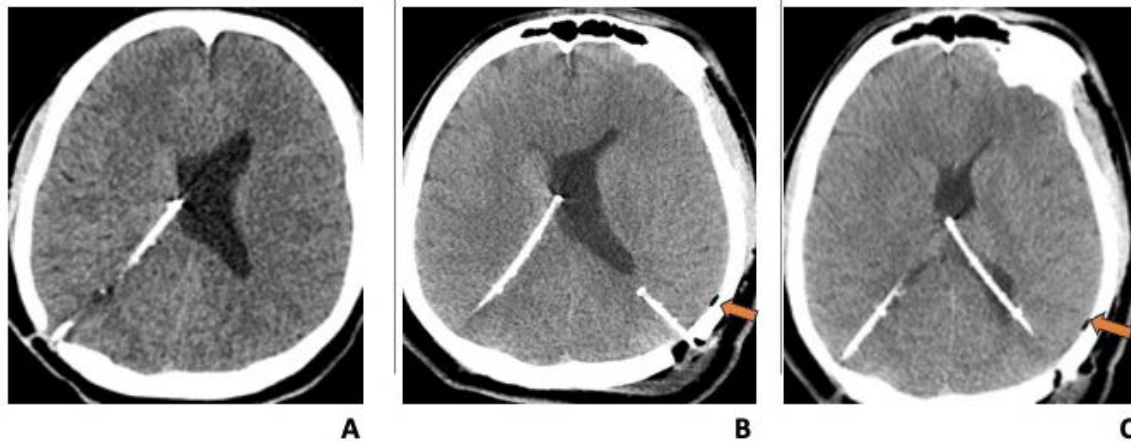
Non contrast Head CT axial image (A) shows slit like right lateral ventricle with a right parietal approach ventriculostomy catheter terminating along the right lateral ventricle and asymmetrically prominent left lateral ventricle. Non contrast Head CT post left side shunt placement axial image (B & C) shows new left posterior parietal approach ventriculostomy catheter crossing the left lateral ventricle, tip at the vicinity of the septum pellucidum with slight interval decrease in size of the left lateral ventricle. Stable right parietal approach ventriculostomy catheter. Pneumocephalus is present (arrow).
